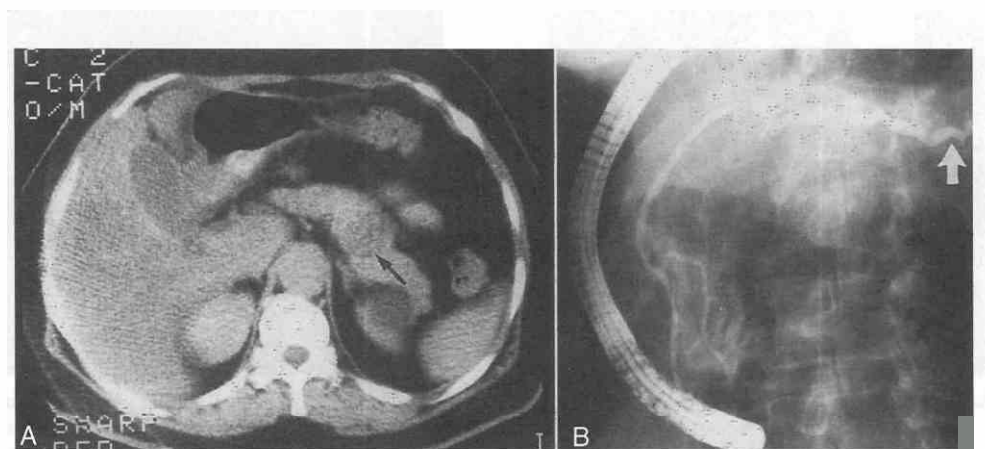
A, CT scan shows an area of decreased density (arrow) within the gland that represents focal pancreatitis. B, ERCP shows enlargement of the duct (arrow) in the central part of the gland; enlargement is typical of pancreatitis.
